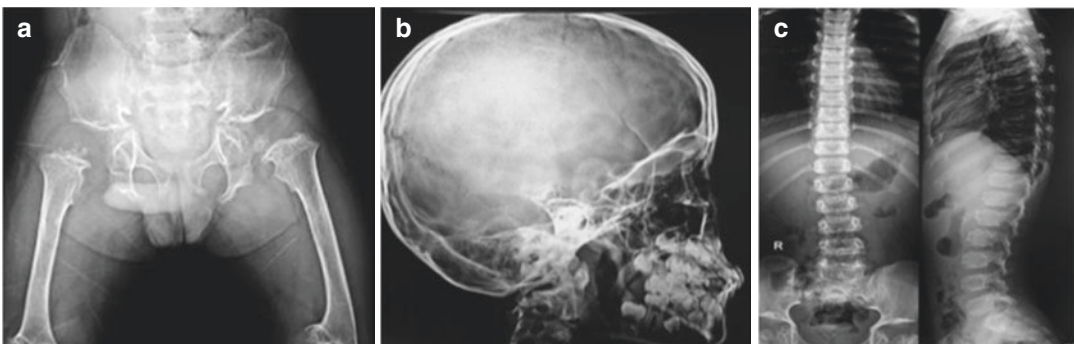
Skeletal survey in a patient with pseudoachondroplasia. (a) Frontal radiograph of the pelvis shows a champagne glass pelvic inlet (same as achondroplasia) along with delayed appearance of bilateral proximal femoral epiphysis which are flattened and fragmented. (b)
